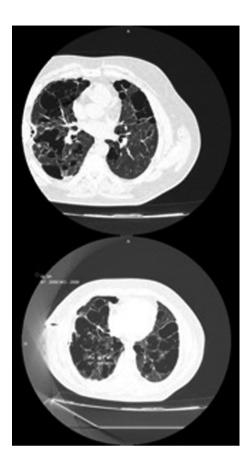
Diffuse thin-walled air cysts (compatible with Langerhans cell histiocytosis) are observed in both the lungs on thoracic CT. CT, computed tomography.
